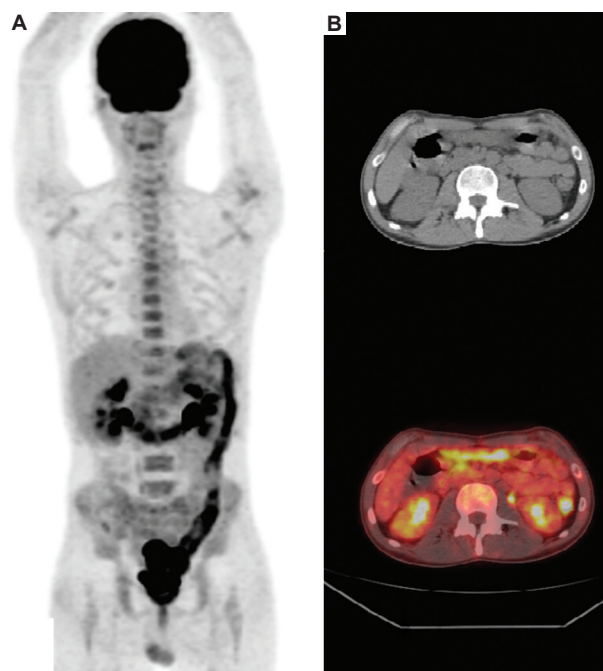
(A) Maximum intensity projection showing physiological and pathological uptake of ¹⁸F-FDG. (B) CT image and fusion image in axial sections showing intense recto-sigmoid uptake (SUVmax = 16.4). Normal digestive uptake due to Biguanide use was ruled out. Biopsy of digestive tract confirmed active ulcerative colitis.
